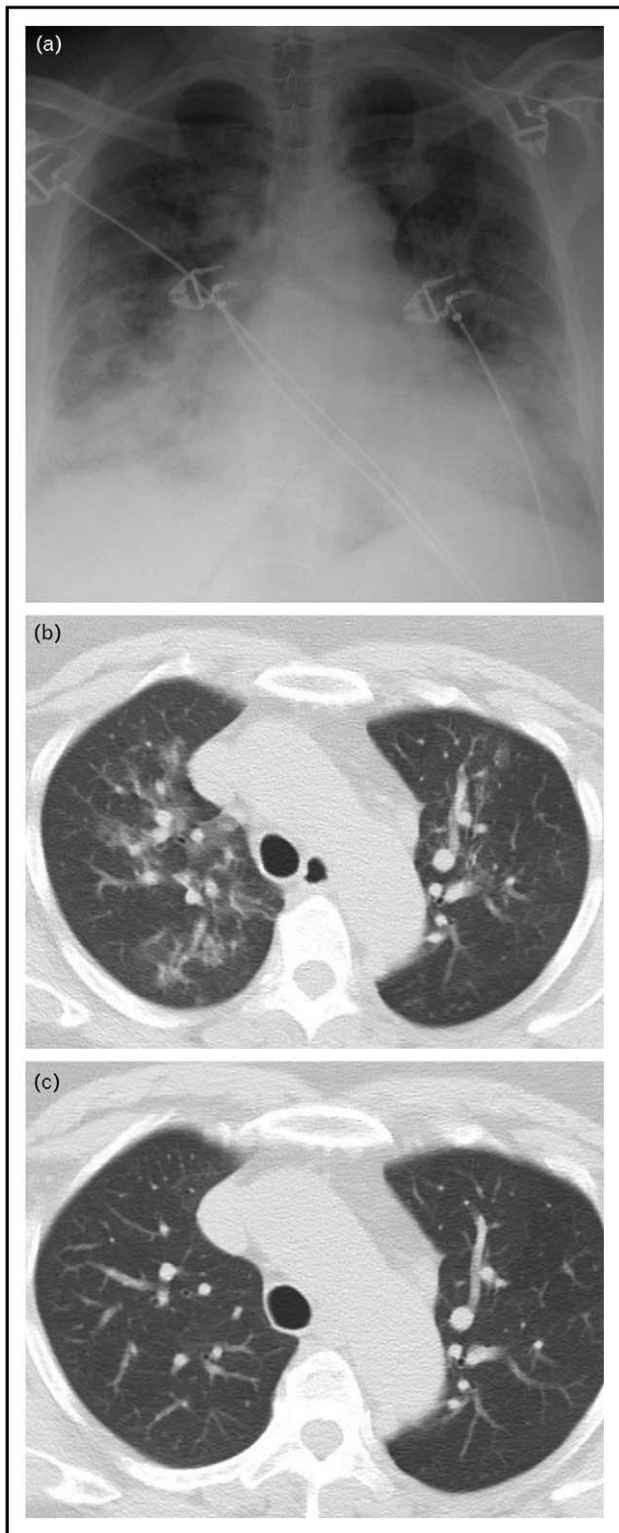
(a) Chest radiograph at admission showing diffuse infiltrates/consolidation. (b) Chest computed tomography showing diffuse consolidations on both lungs with central distribution. (c) Chest computed tomography 3 months later showing substantial improvement.
